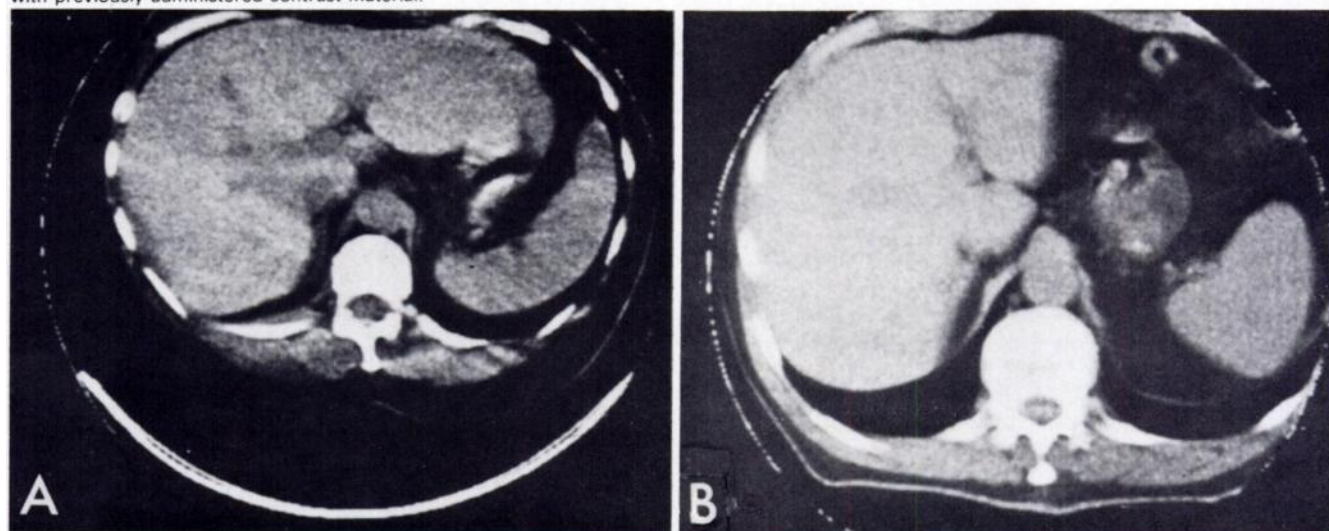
CT scans of two normal livers showing variation in size and shape of left hepatic lobe.
